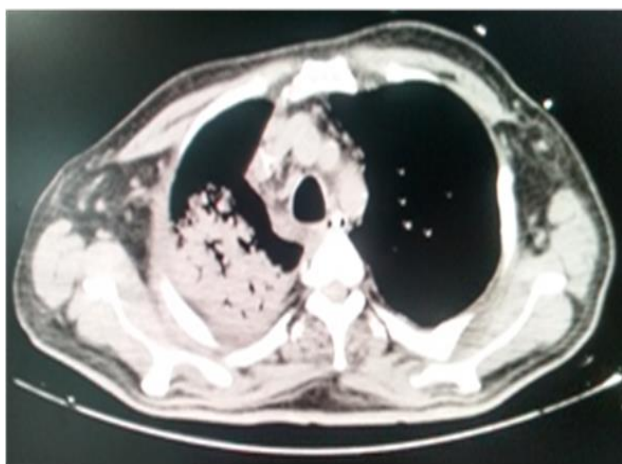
CT Thorax showing chronic bronchiectatic changes in the right middle lobe.
